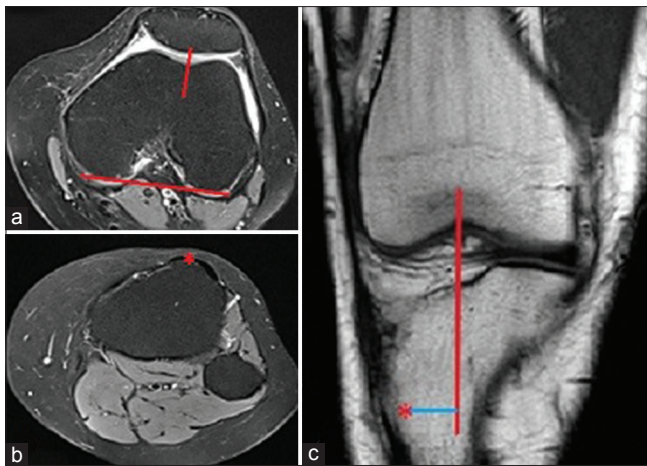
Axial magnetic resonance imaging images at 3 cm above the tibiofemoral joint cleft (a) and through tibial tuberosity (b), and a coronal magnetic resonance imaging section (c) demonstrating the tibial tuberosity to trochlear groove distance measurement method
